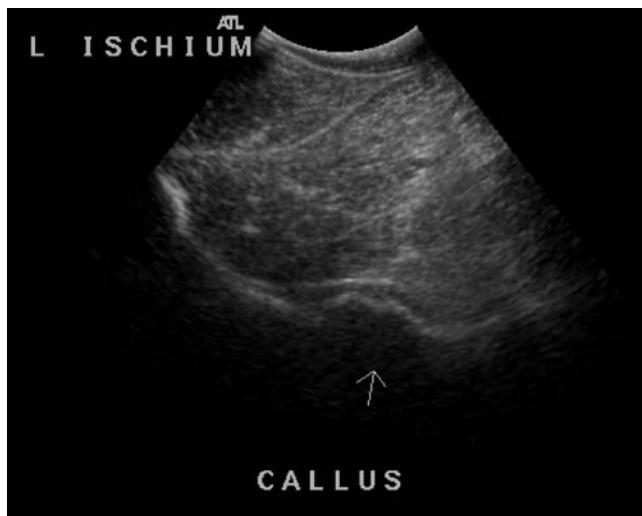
Follow-up ultrasound examination of the fracture site 7 weeks post injury showing callus formation.
